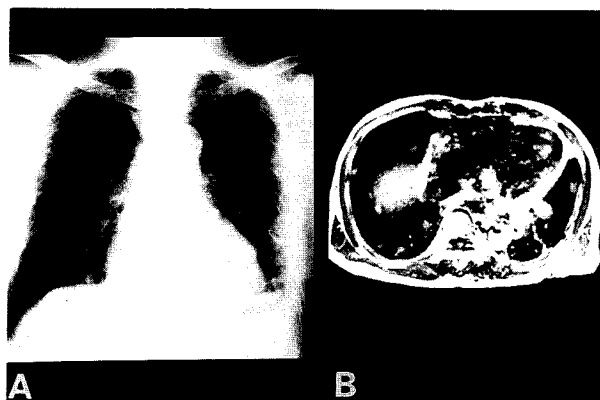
Chest roentgenogram (A) and MRI (B) examination showed multiple nodular lesions in bilateral lower lung fields.
